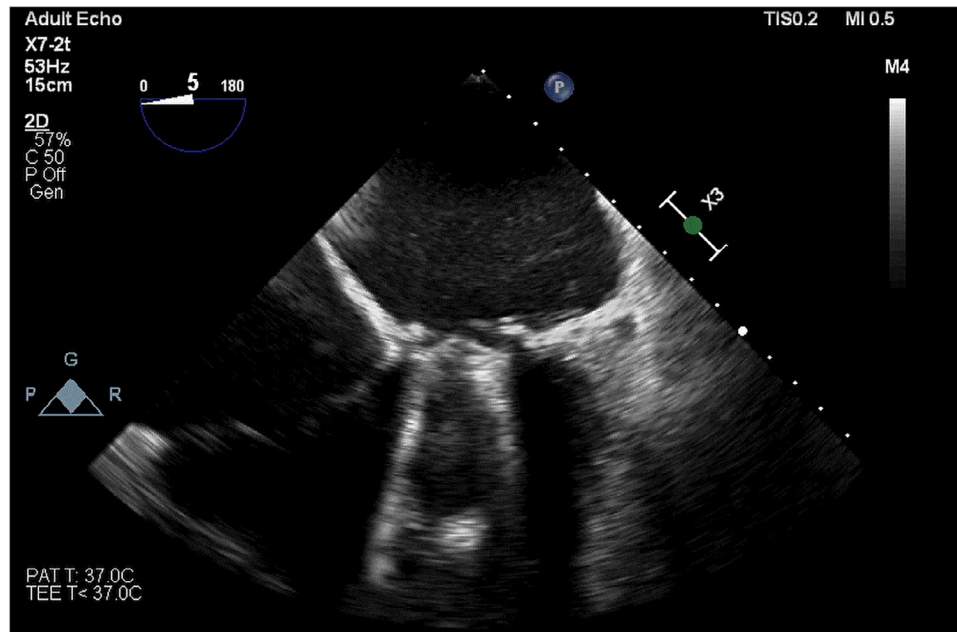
Transesophageal echocardiography (Phillips EPIQ 7C) in mid-esophageal 4 chamber view depicting prosthetic mechanical mitral valve.
